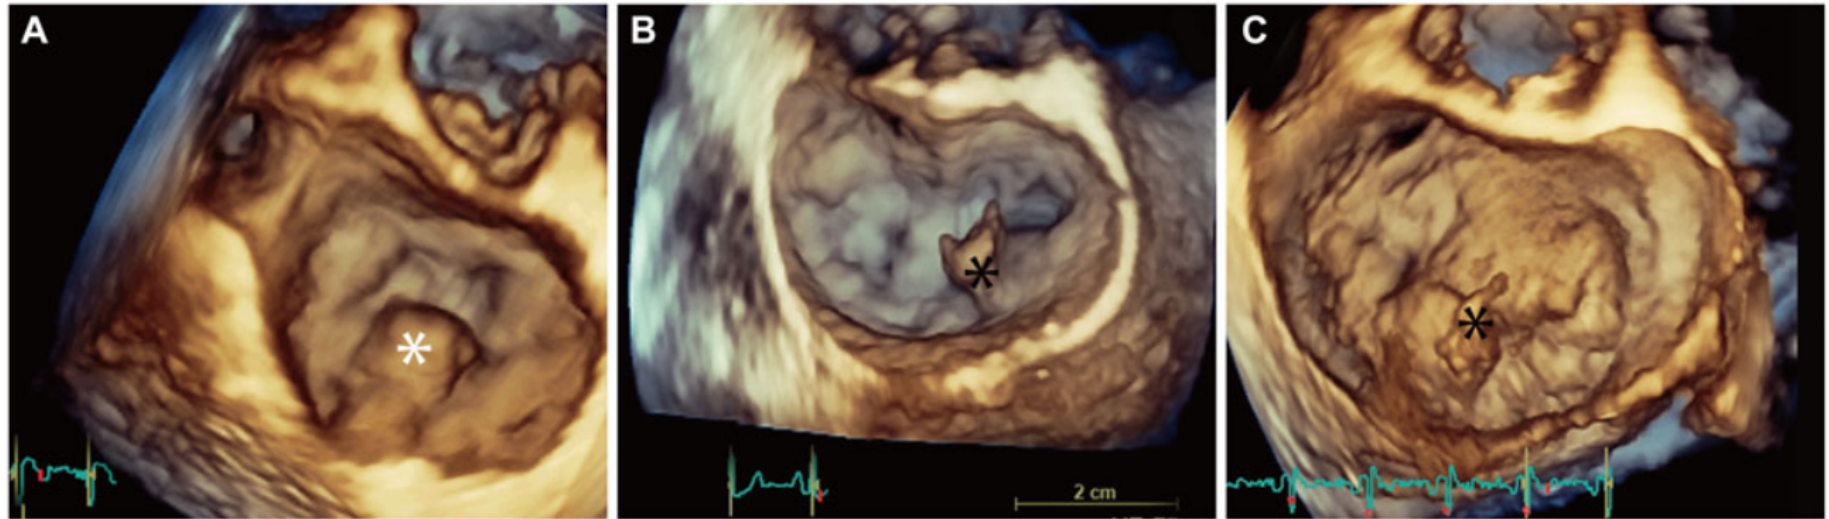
Mitral valve lesions in severe organic mitral regurgitation, assessed by three-dimensional transoesophageal echocardiography. A: severe mitral regurgitation determined by a simple lesion with a high probability of successful mitral valve repair. 3D transoesophageal surgical view of the mitral valve showing isolated P2 scallop prolapse (asterisk) ([Supplementary Video 1](#) in the online-only Data Supplement). B: severe mitral regurgitation determined by complex lesions with a possibly successful mitral valve repair by an experienced surgeon. 3D transoesophageal surgical view of the mitral valve showing P3 scallop prolapse and flail (asterisk) involving the posterior commissure ([Supplementary Video 2](#) in the online-only Data Supplement). C: severe mitral regurgitation determined by a very complex lesion with an unlikely chance of successful mitral valve repair. 3D transoesophageal surgical view in a patient with Barlow disease and P2 flail (asterisk) ([Supplementary Video 3](#) in the online-only Data Supplement). 3D: three-dimensional.
